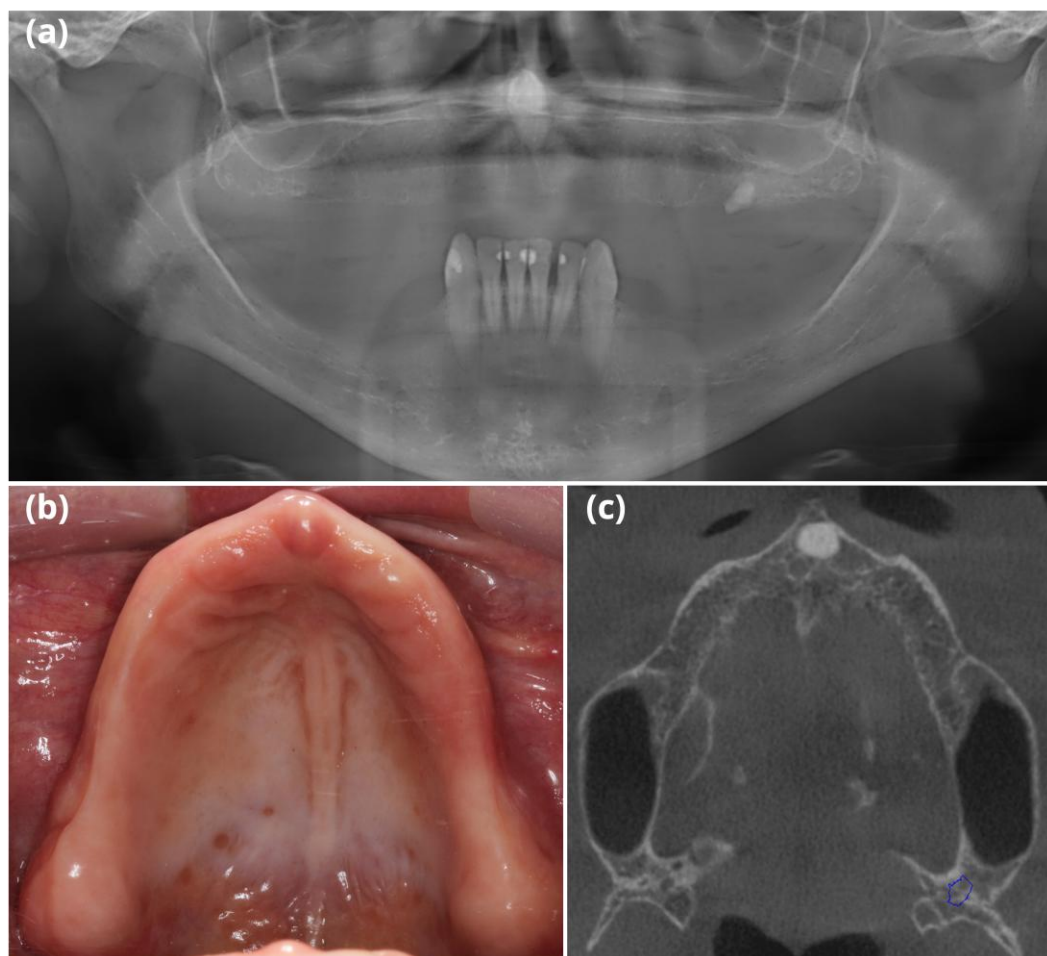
Initial condition case report 1. Panoramic radiographic (a). Clinical condition (b). Treatment planning of the implant in the pterygoid region (c).
